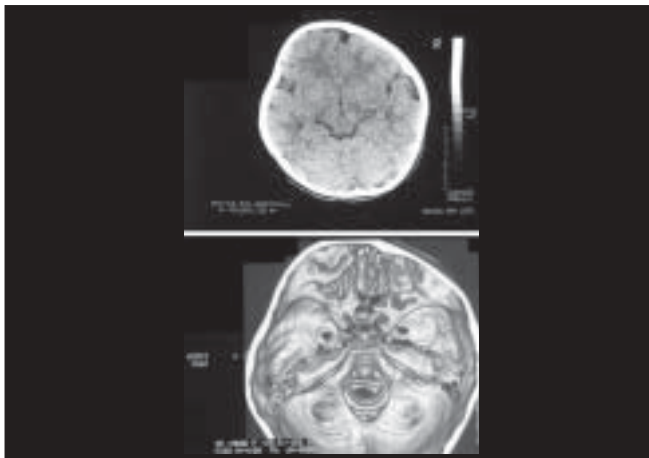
The upper axial scan shows the right-sided flattening of the skull when the girl was two years old. The lower three-dimensional CT scan clearly shows right side frontal plagiocephaly
